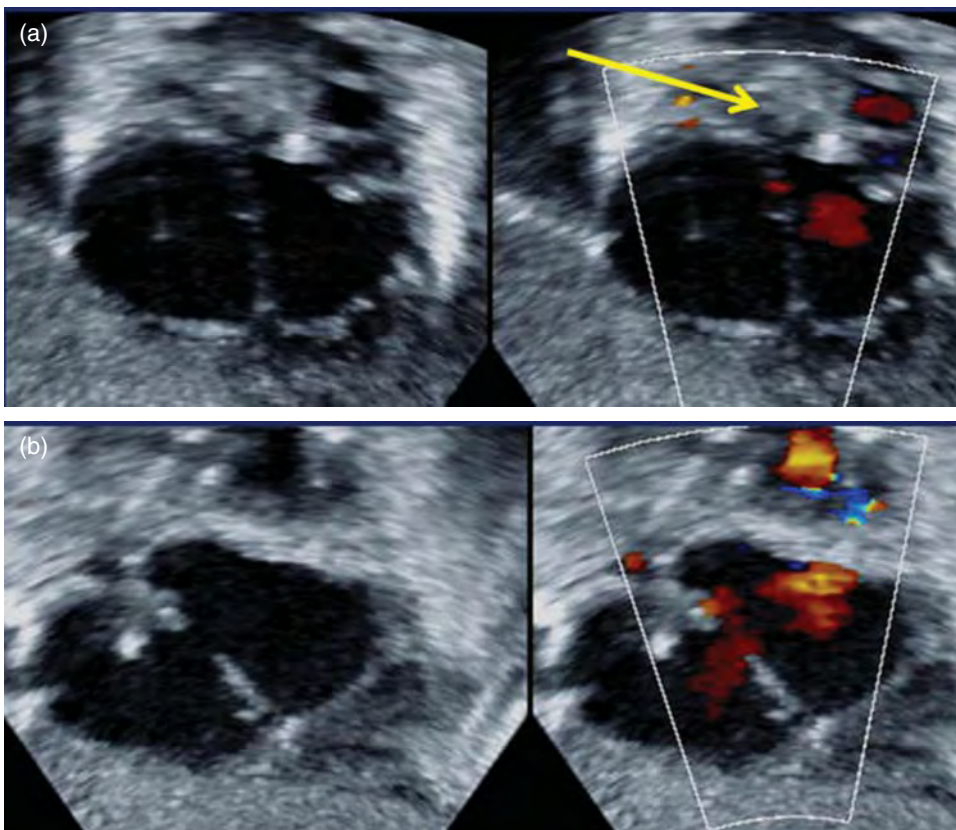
(a) Echocardiogram: subcostal coronal view showing the atrial septum prior to balloon atrial septostomy, with a tiny patent foramen ovale seen on the color image, with red color showing flow from the left atrium to the right atrium. (b) Atrial septum of the same patient following balloon atrial septostomy. Note the much larger hole in the atrial septum, with red color depicting a wide jet of left atrial to right atrial flow.
